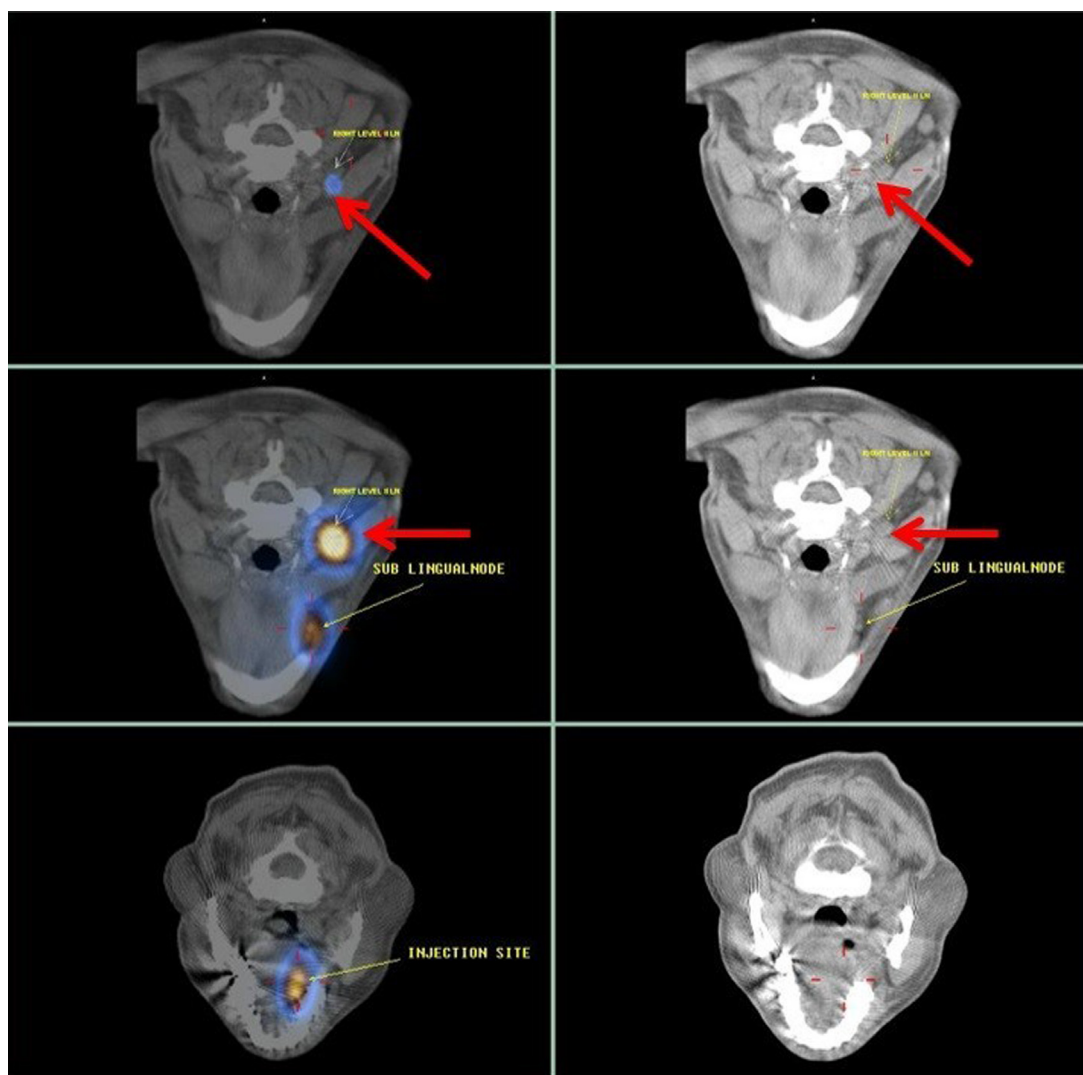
SPECT/CT image showing injection site and lymph nodes in CT and fusion images. Red arrow demonstrates right level II cervical lymph node. Right sublingual lymph node and injection site are also represented in the picture.
